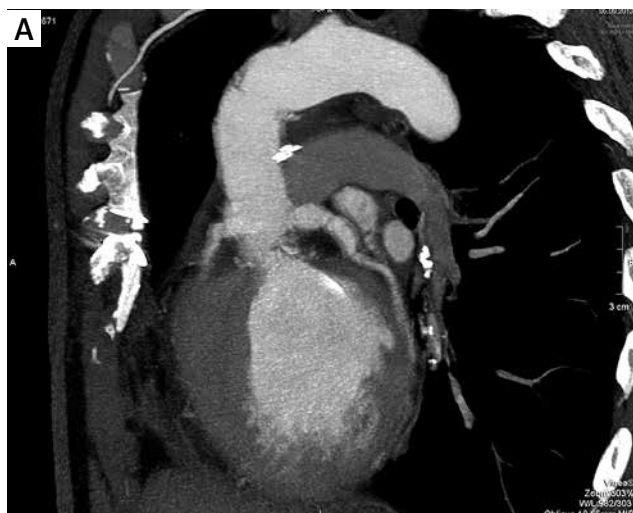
Post-operative images of the aortic annulus/root using the same computed tomography (CT) techniques
